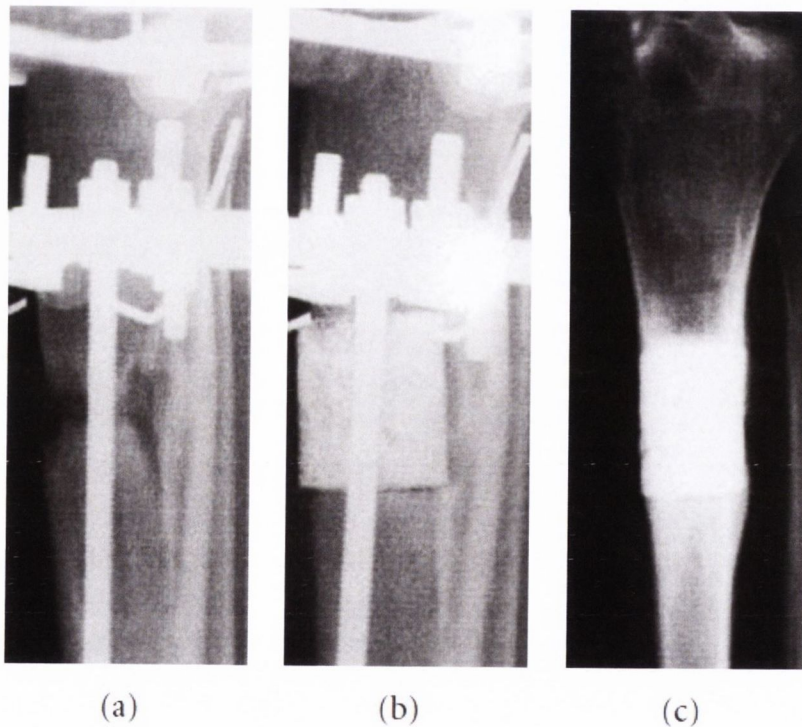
Radiographs Obtained before and after the Repair of Large Bone Defects. Panels A, B, and C show films obtained from Patient 1 before, immediately after, and 18 months after surgery, respectively.
